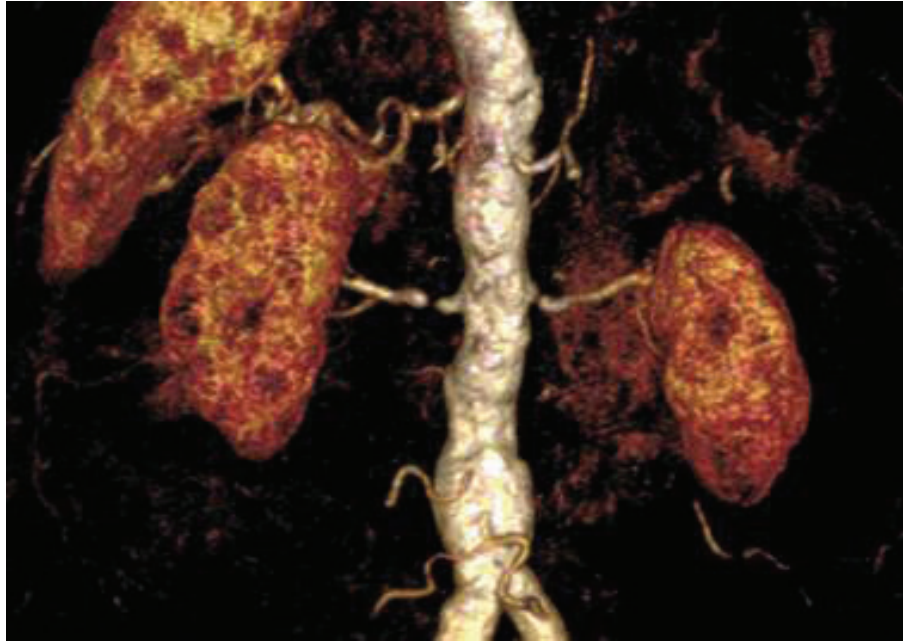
3D volume computer visualization of MRI renal and splenic angiogram data acquired at Ninewells Hospital, Dundee, UK
